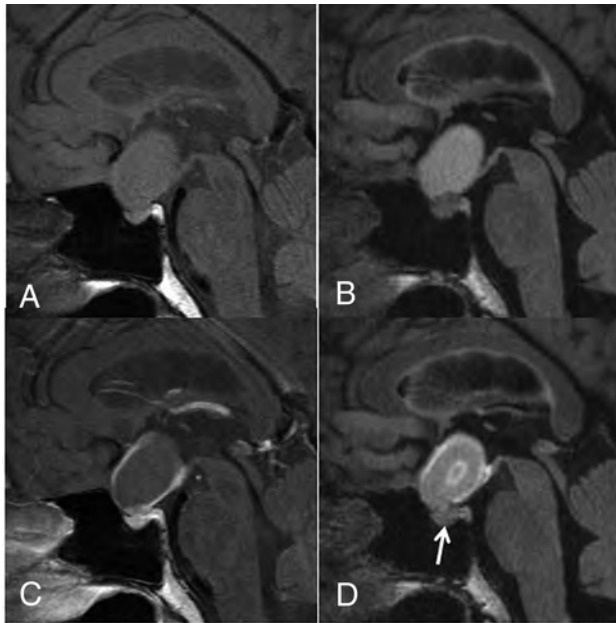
A 44-year-old woman with a CCP. A comparison of pre- (A) and postcontrast T1WI (C) shows that the cyst wall is enhanced on the postcontrast image (grade 2). A comparison of pre- (B) and postcontrast 3D T2-FLAIR images (D) reveals enhancement of the cyst wall (grade 2) and the lesion center on the postcontrast image (D). Different from the postcontrast T1WI (C), the pituitary gland is not intensely enhanced on the postcontrast 3D T2-FLAIR image (arrow in D). The observer judged this lesion as probably an RCC (scale 2) at the conventional MR interpretation, whereas the confidence level was changed to probably a CCP (scale 4) by the addition of 3D T2-FLAIR interpretation.
